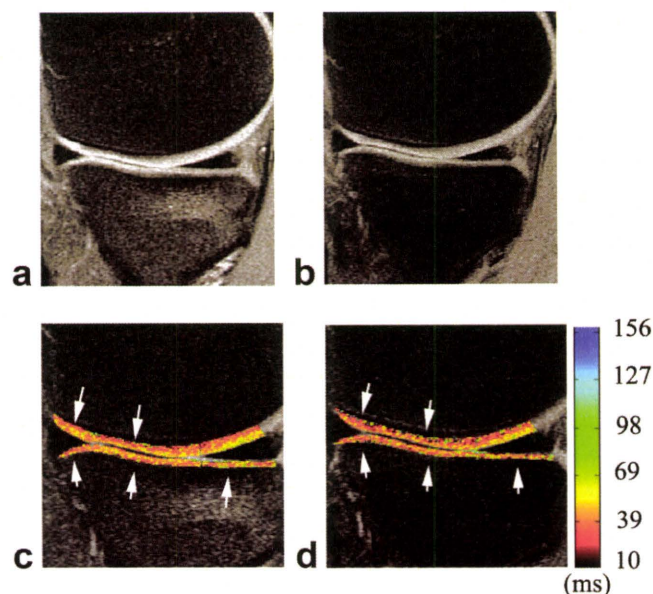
MR images and T2 maps of cartilage in the medial femorotibial joint of a 22-year-old female volunteer. a,b: Sagittal MR images (1500/15) under unloading and loading conditions. There was no significant difference in cartilage thickness between unloading and loading conditions. c,d: T2 maps of the cartilage in the examined ROIs under unloading and loading conditions. On the color-coded T2 map a low T2 value is represented by red color and a high T2 value is represented by green or blue color. Under loading conditions a decrease in T2 was observed in the femoral and tibial cartilage (arrows).
